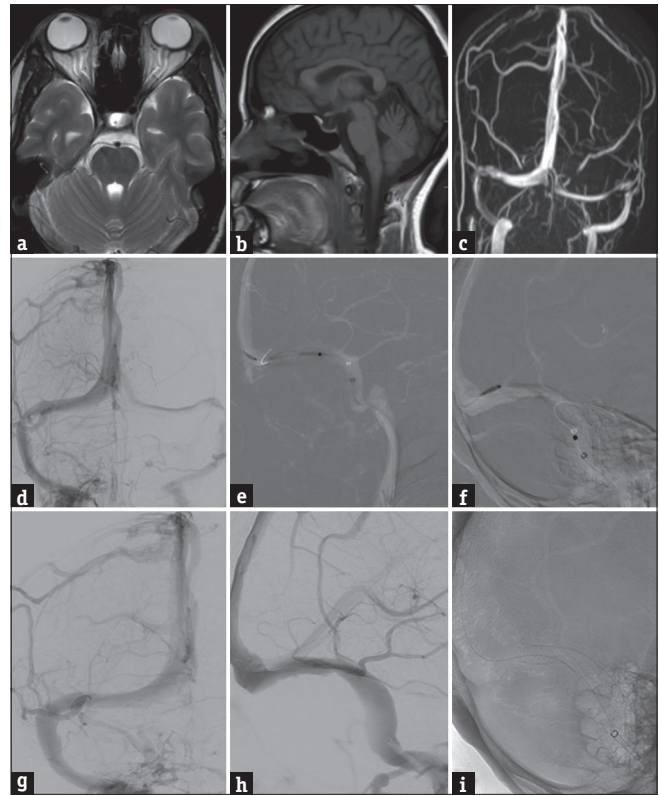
(Case 1) Magnetic resonance imaging brain with magnetic resonance angiogram. (a) T2-weighted (T2W) axial section showing bilateral tortuous optic nerve with increased peri-optic space and flattened posterior sclera. (b) T2W sagittal section showing empty sella sign; (c) T2W axial section showing slit like lateral ventricles. (d-f) MR Venogram (MRV) showing significant left transverse sinus stenosis and hypoplastic right transverse sigmoid sinus
